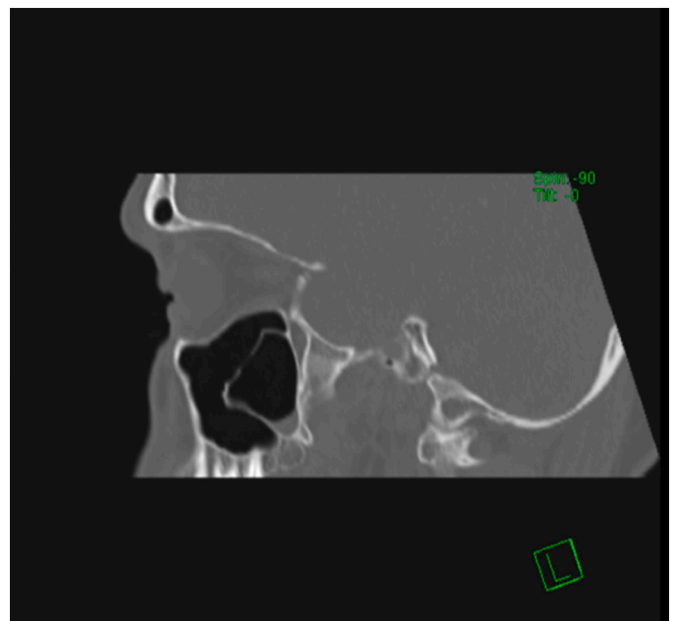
Sagittal section of CT air cell in the right maxillary sinus associated with a partially calcified polypoidal mucosal thickening.
